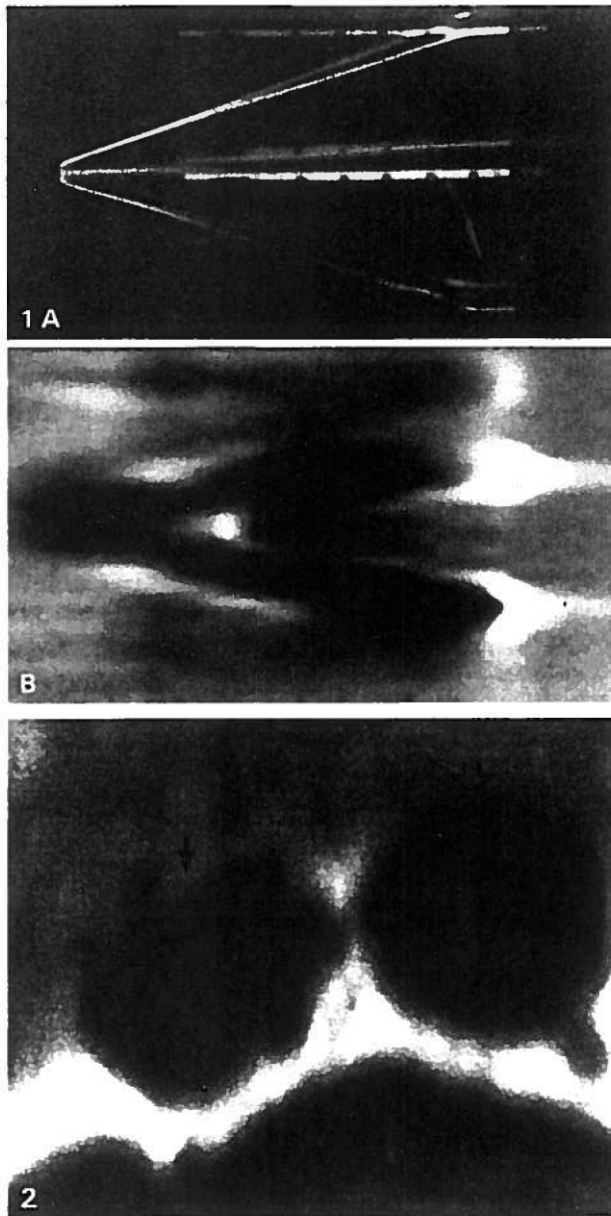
A AP image of invested filter 2 ma at 46 kVp (above). B Coronal MR image of invested filter [TR 60, TE 15].
